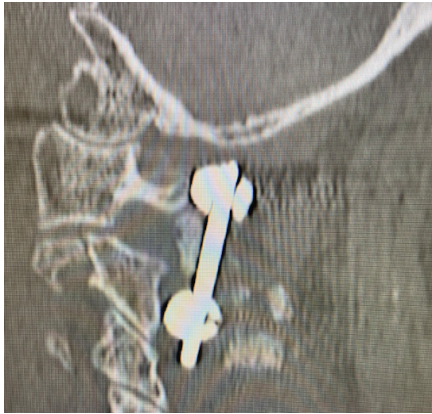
Sagittal CT Scan following initial fusion.
